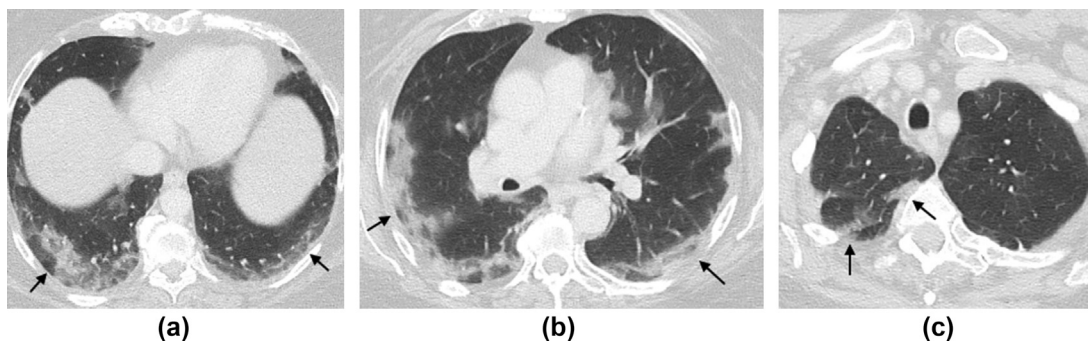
Patient with classic/probable COVID-19 CT features identified (black arrows) at (a) lung base, (b) limited chest (below carina), and (c) whole chest (above carina).
